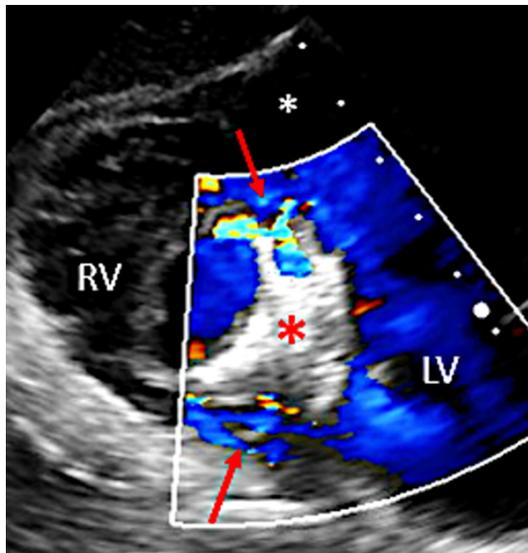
Left to right shunt. A pure left-to-right shunt across the ventricular septum, as seen on color doppler via TEE transgastric view, through the VSR (circle). LV, left ventricle, RV, right ventricle.
